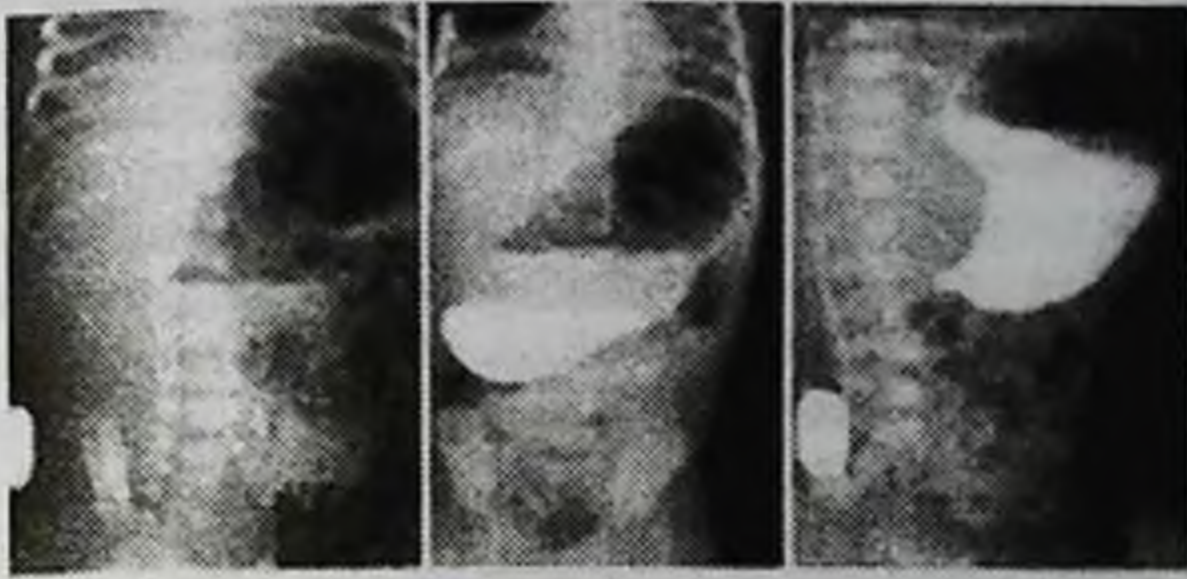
(a, b, c). X-ray contrast study of the stomach.
